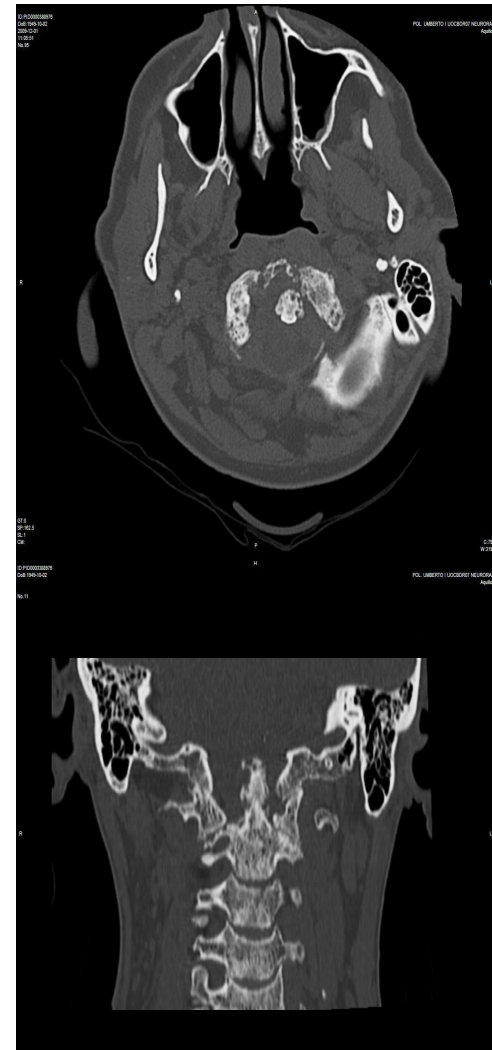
Computed tomography shows a fracture of the odontoid-process that appeared dislocated, with conglomerated osteolytic lesions with a sclerotic rim in the atlas-axis-C3 and C4 vertebral bodies.
